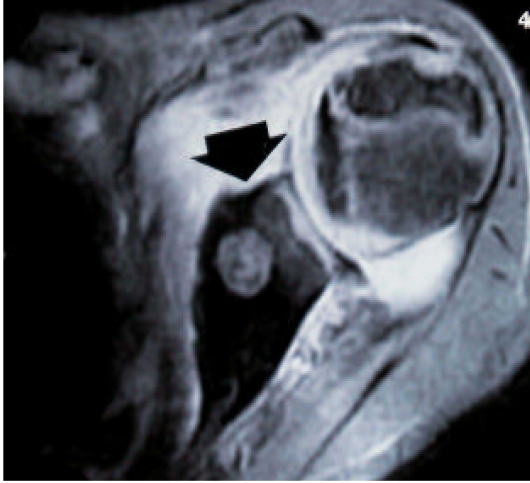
MRI appearance of the case. Note extent of the tumor
